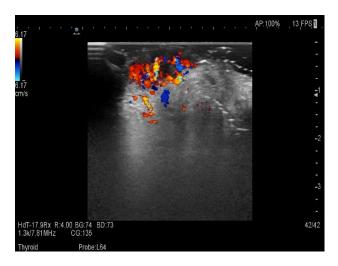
Color doppler showing highly vascular nature of the lesion.
